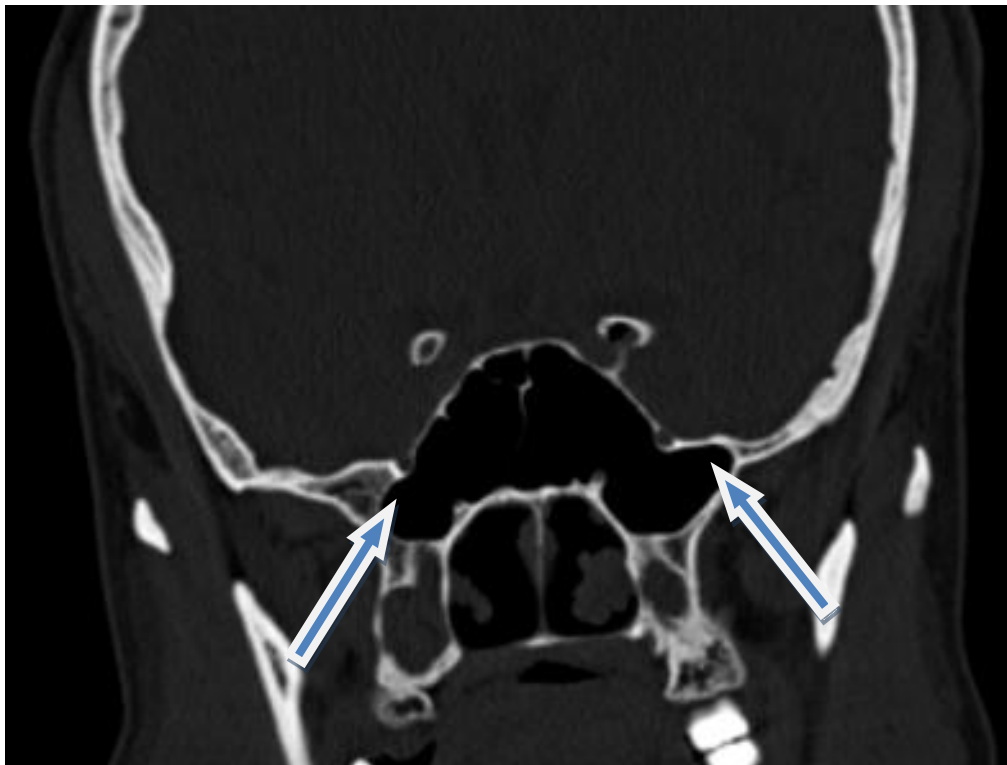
CT coronal section of sphenoid sinus showing pneumatization of greater wing of sphenoid.
